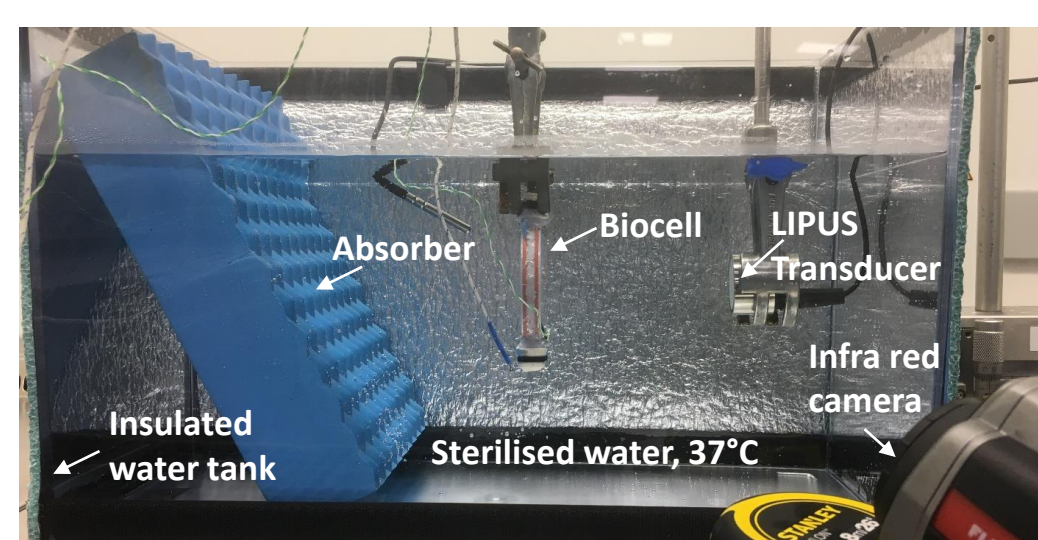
Proposed ultrasound exposure set-up
